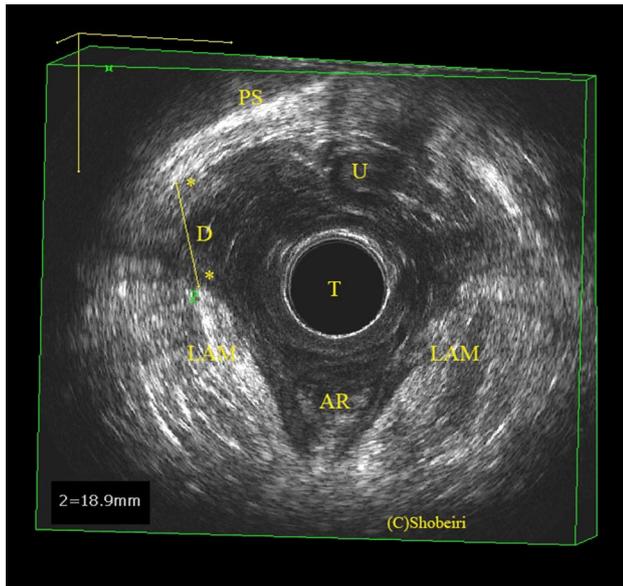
Axial view obtained with 3D endovaginal ultrasound demonstrating a right postpartum persistent levator ani muscle defect 6 months after delivery. The pubic-levator distance of 18.9 mm is highlighted with asterisks*
